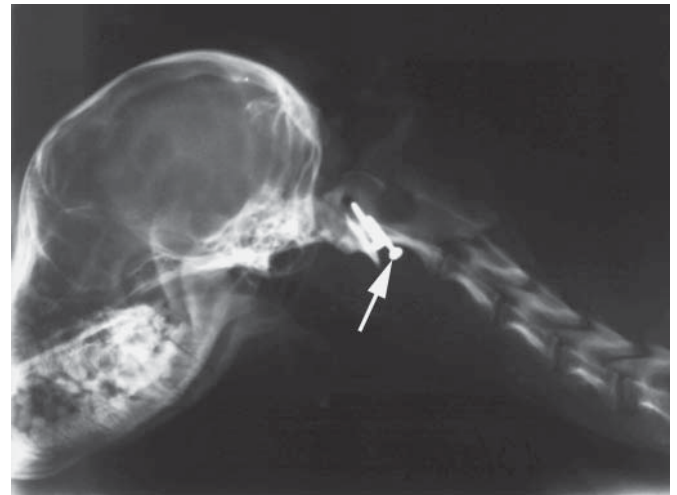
Lateral radiograph of a Yorkshire terrier (case No. 5) following an accident 20 days after surgery. One screw is displaced caudally (arrow). The distance between the dorsal arch of the atlas and the dorsal spine of the axis is normal.
